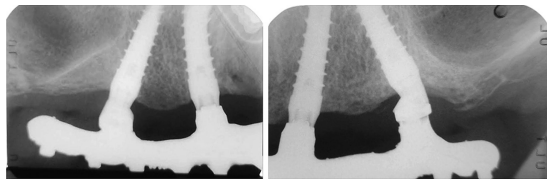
Radiographic images at the 1-year follow-up visit (T12).
